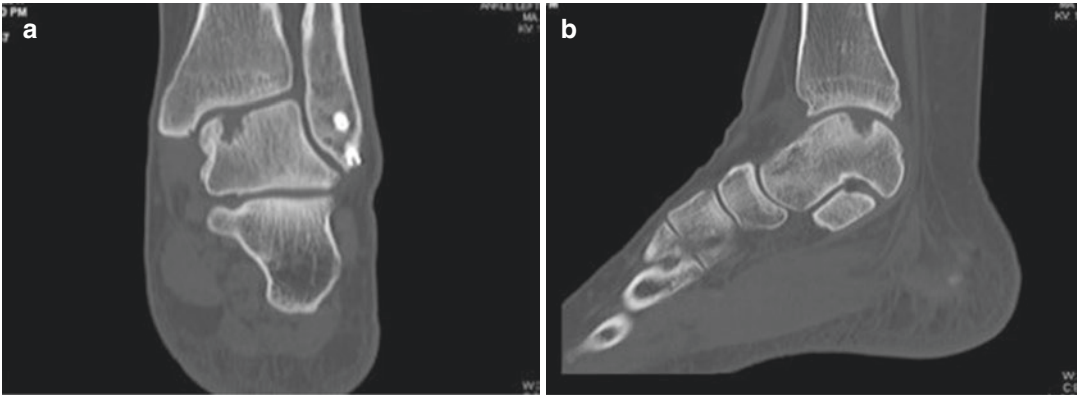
Preoperative CT of a left ankle with a cystic osteochondral lesion. (a) Coronal view demonstrating medial location of the cystic osteochondral lesions. (b)
